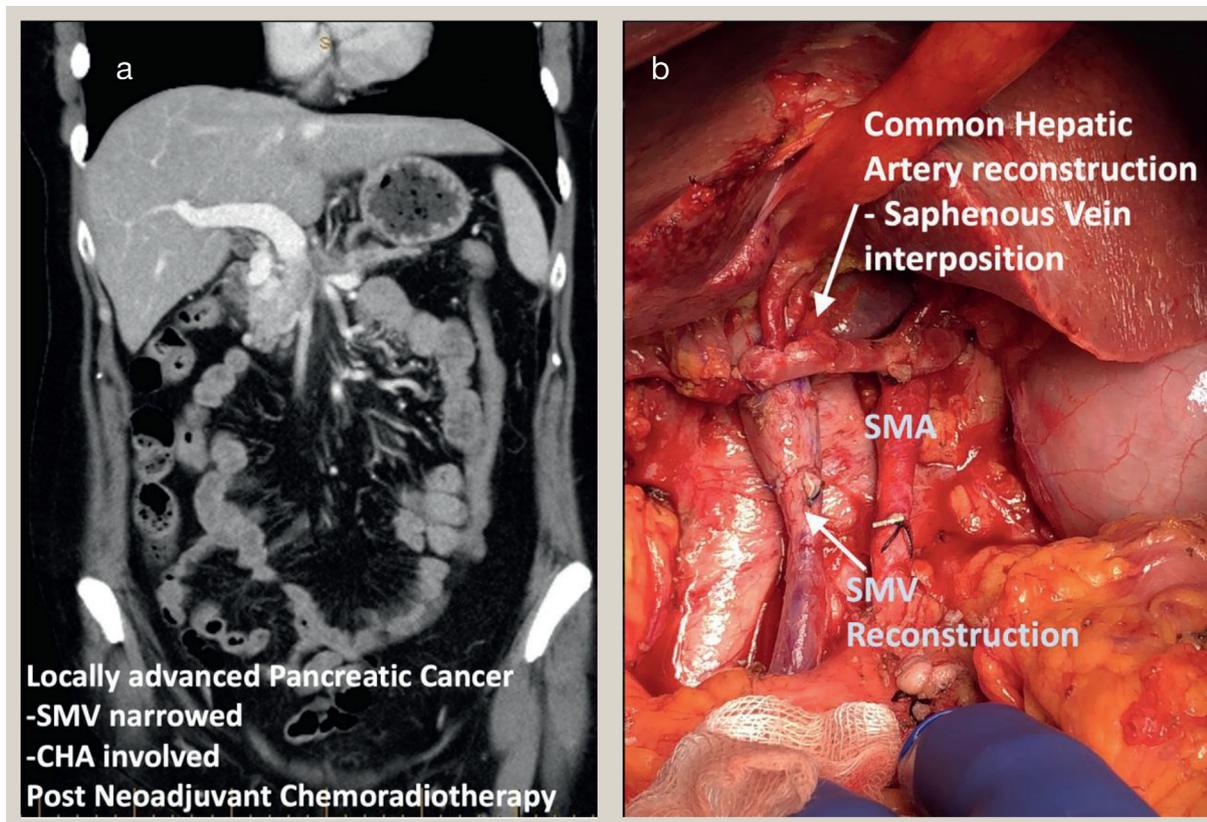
(a) Axial CT scan of a hypoattenuating locally advanced pancreatic cancer. (b) Post-resection intraoperative image with complex common hepatic artery and SMV reconstruction.
